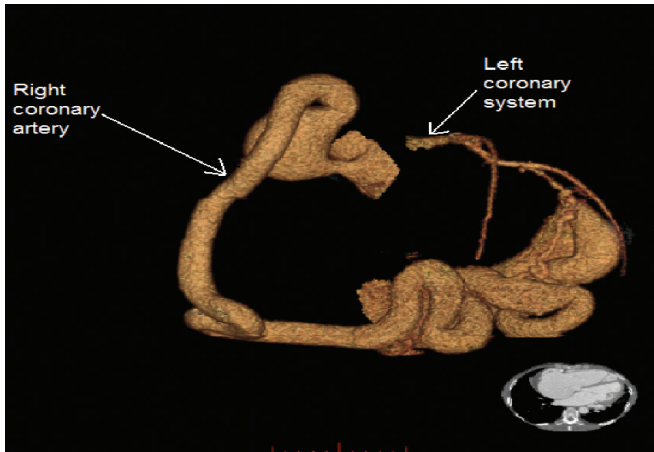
Computed tomography coronary arteriogram showing the course of the hugely dilated right coronary artery, plus the left coronary artery.
